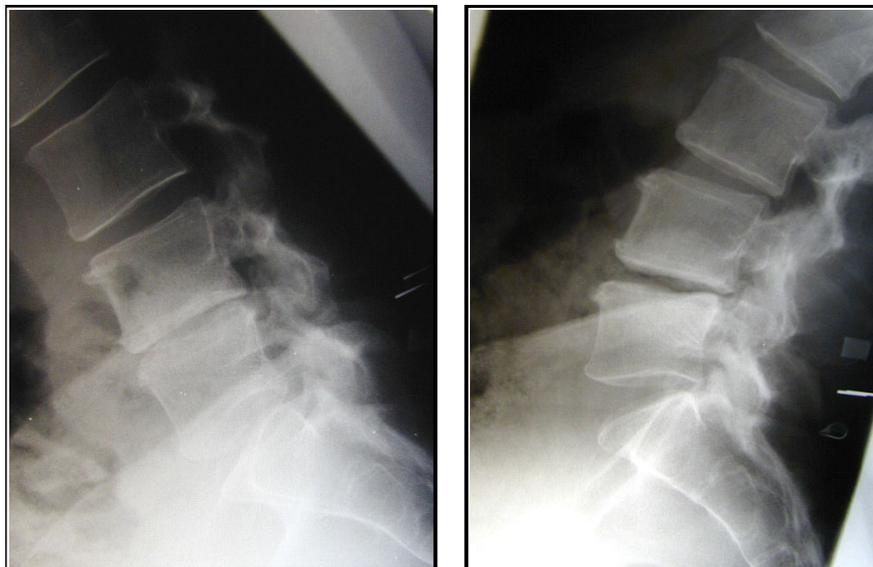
X-rays taken while bending forwards (left) and arching backwards (right) three months after surgery, showing how movement is preserved.
